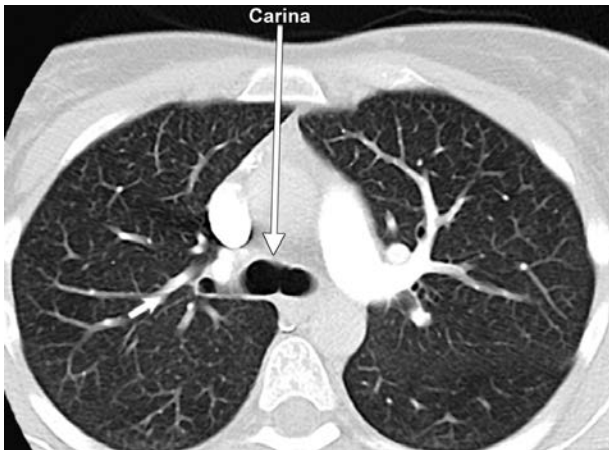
CT chest showing tracheal division into the right and left main stem bronchi. Note the cross-sectional cut of the right upper lobe (thick arrow). Of note, a patchy area of hazy opacity is seen in the left upper lobe laterally
